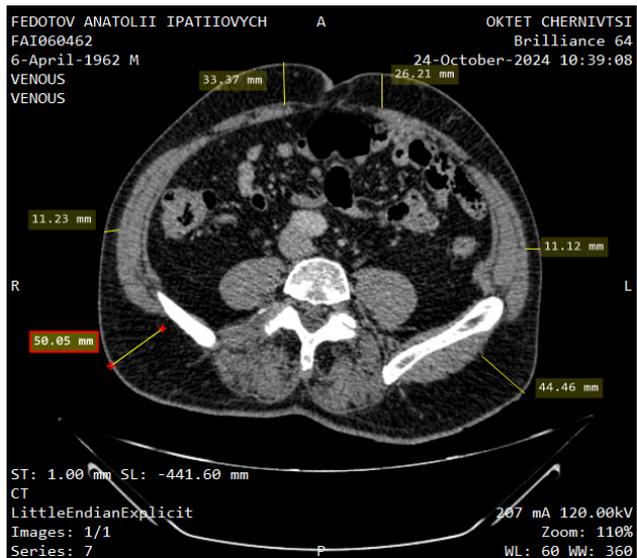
CT scan of patient F., 62 years old with excess body weight, performed at the navel level. Subcutaneous fat thickness from 11.12 to 50.05 mm.
